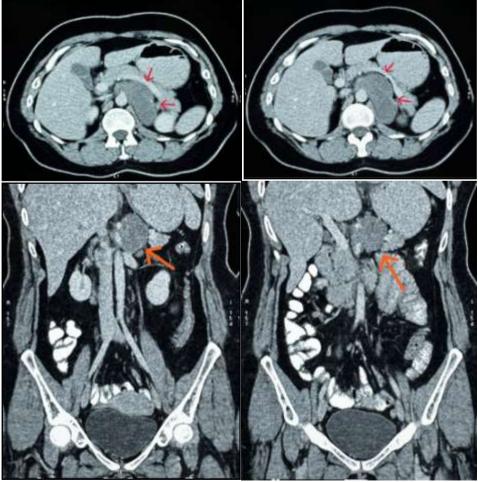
CT scan showing the retroperitoneal tumour marked by arrows.
